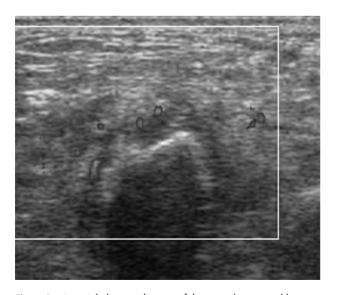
An axial ultrasound image of the second metatarsal bone showed distinct cortical thickening with periosteal haematoma and power Doppler signal.
